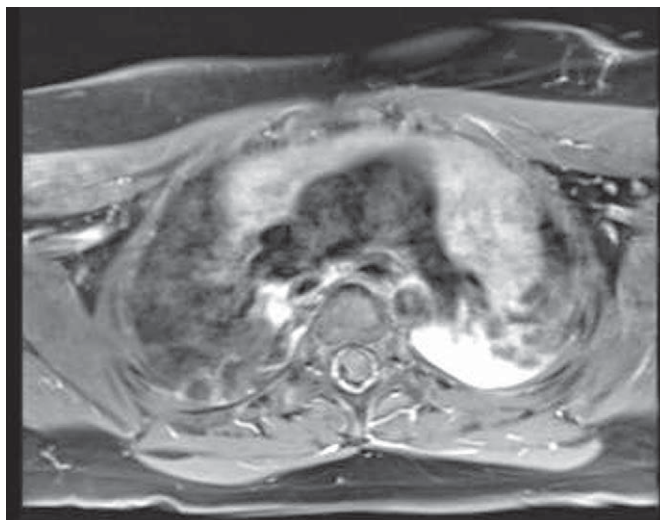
Magnetic resonance imaging of the chest in patient 2 reveals an enlarged thymus.
